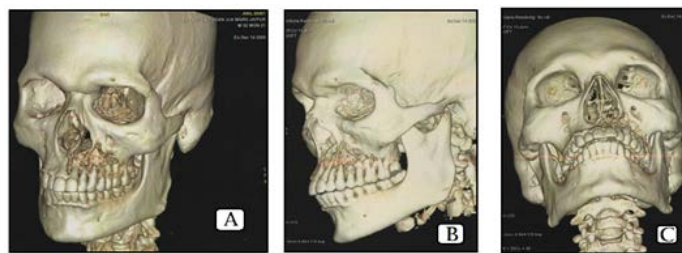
3D CT scan of face showing osteolytic activity on left anterior maxillary region due to mucormycosis.
